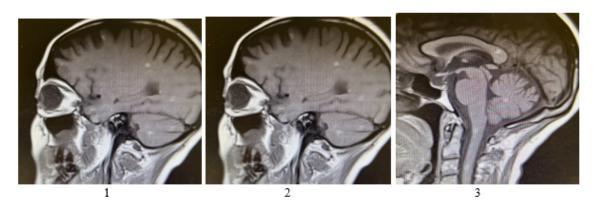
MRI brain June 2017.
